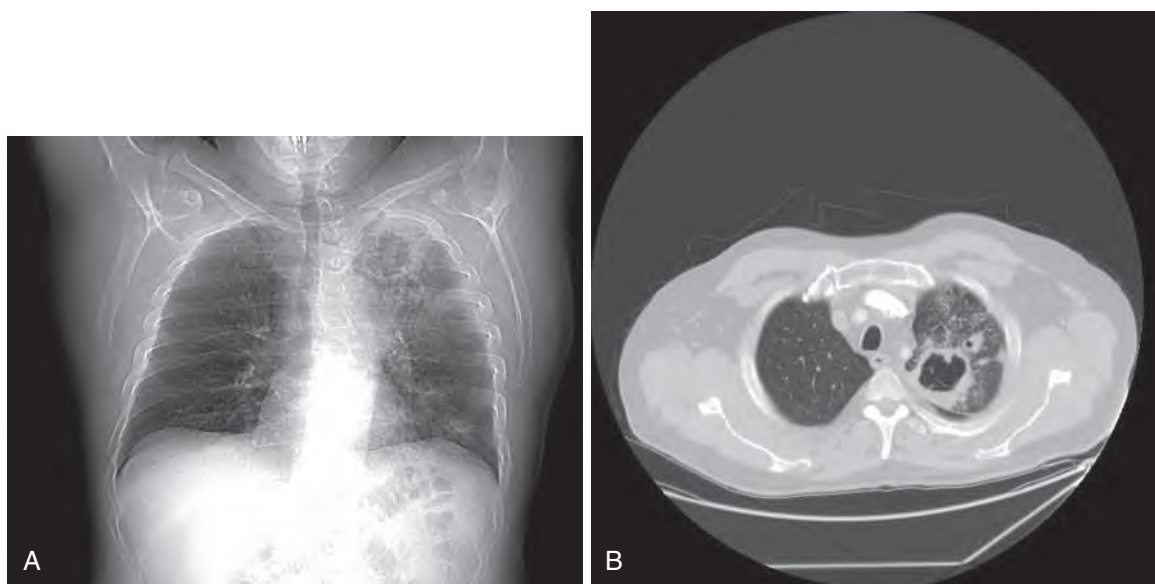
(A) This 59-year-old white male has a recent diagnosis of small cell carcinoma upper lung involving the right lung and mediastinum. He is also noted to have a cavitary lesion and cough productive of yellowish sputum progressive over the past 6 months. He lives in southern Texas near the Mexican border. Serology was positive for *Coccidioides*, and the organism was isolated from multiple expectorated sputum samples. (B) A computed tomography scan from the same patient reveals a large cavitary lesion in the left upper lobe, with some surrounding parenchymal infiltrates consistent with a diagnosis of chronic fibrocavitary pulmonary coccidioidomycosis.
